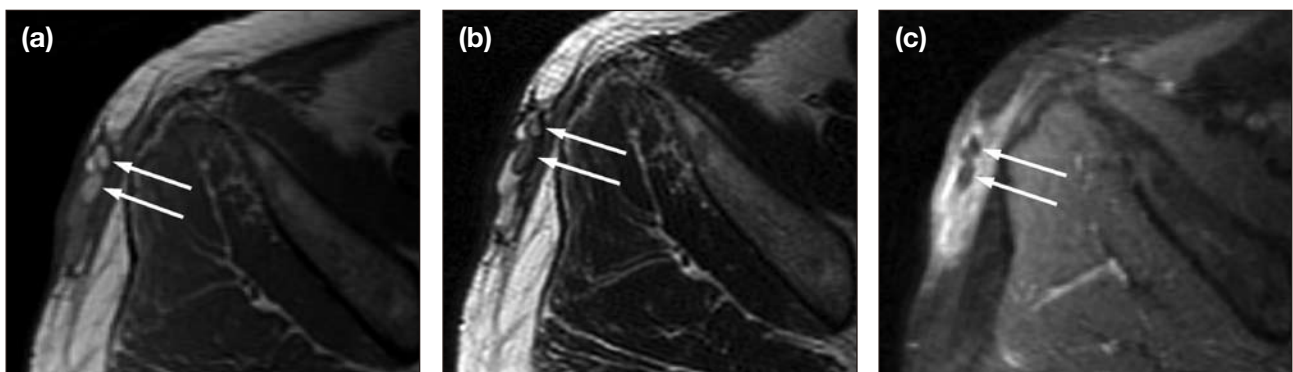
Axial magnetic resonance images showing T1-weighted hyperintense, T2-weighted hypointense, and non-enhanced blood products (arrows) at the lesion's periphery. (a) T1-weighted image; (b) T2-weighted image; and (c) Gadolinium-enhanced and fat-saturated T1-weighted image.
